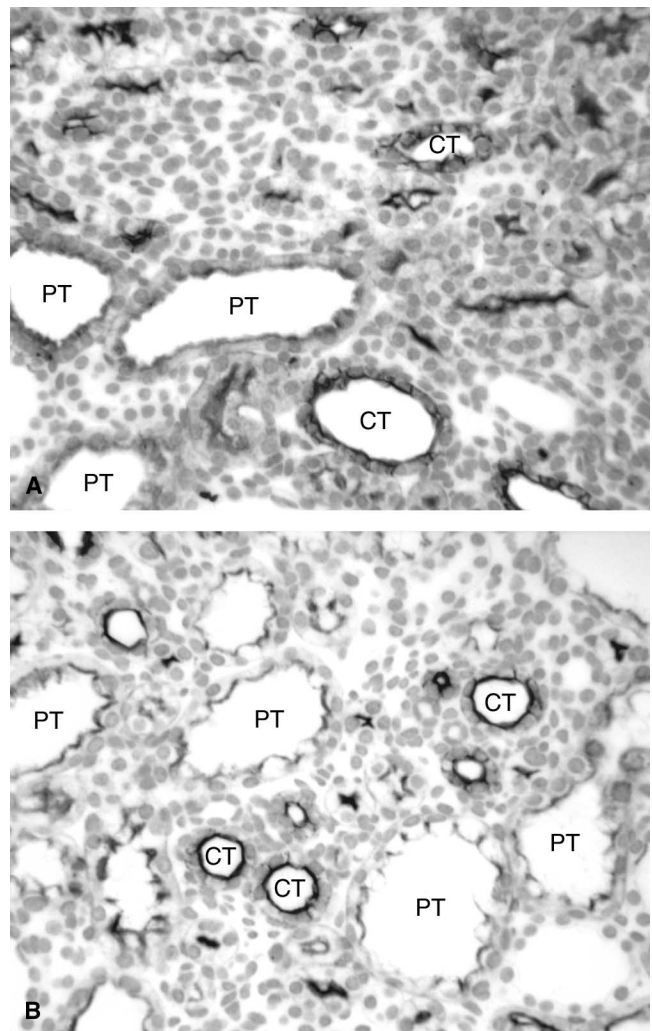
Morphologic comparison of (A) EKB in combination with WTACE2 and (B) EKB alone, in postnatal day 21 BPK kidneys. Shown are *Lotus tetragonolobus* (LTA)-labeled proximal tubules (PT) and *Dolichos biflorus* agglutinin (DBA)-labeled collecting tubules (CT). Data demonstrate that EKB-569 treatment (30 mg/kg every 3 days) in combination with WTACE2 (100 mg/kg on intervening days) results in dramatic reduction in size and number of collecting tubule cystic lesions equivalent to the reduction of collecting tubule cyst growth with EKB-569 (90 mg/kg every 3 days) alone. The dose of EKB-569 can be reduced by 67% when used in combination with WTACE2 (original magnification 40×).
